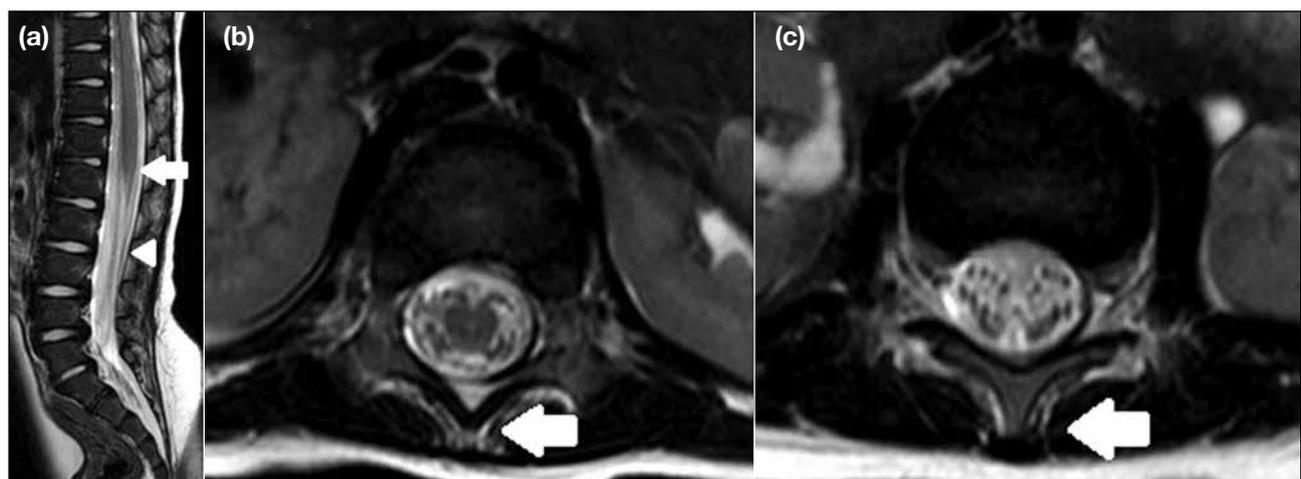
Normal T2-weighted magnetic resonance imaging (MRI) of the lumbosacral spine: (a) A sagittal image shows the normal appearance of the conus medullaris (arrow) at level of L1 and cauda equina (arrowhead). Axial images show (b) the conus medullaris and (c) the cauda equina at a lower level. Note the intact posterior vertebral elements (arrows).
